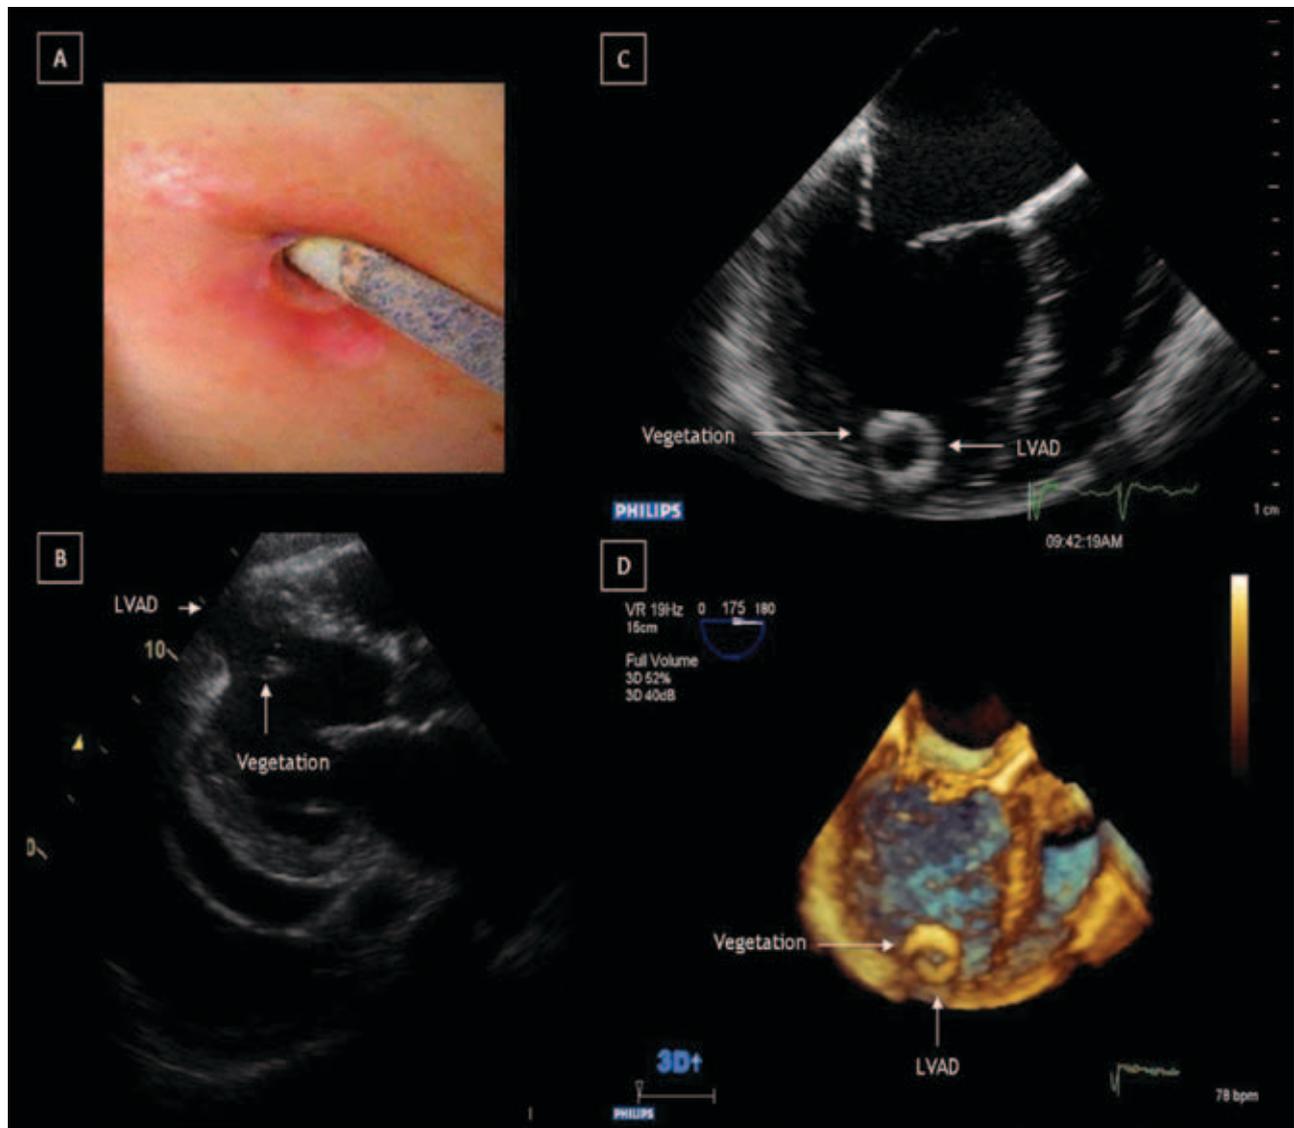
A. Left ventricular assist device (LVAD) exit site infection. B. Two-dimensional long-axis view reveals an echogenic material protruding from the inflow cannula of the device to the left ventricle. Moderate pericardial effusion and enlargement of the coronary sinus are also visible. C. Two-dimensional transoesophageal echocardiography revealed a thickened echogenic material (cross-section of the inflow cannula). D. Real-time three-dimensional echocardiography revealed a thickened echogenic material (cross-section of the inflow cannula).
